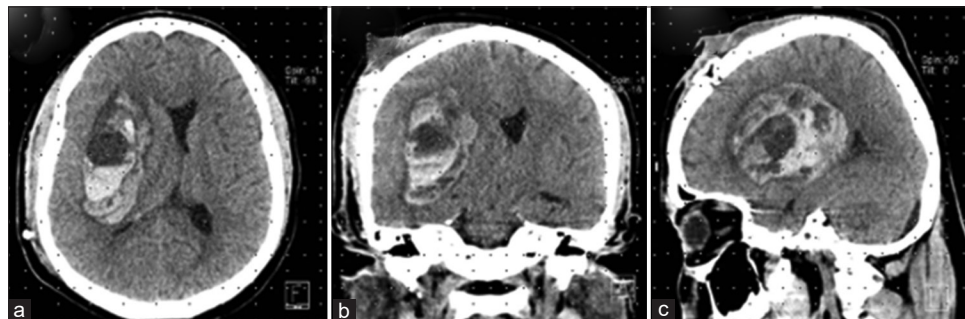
Simple computed tomography scan: (a) axial, (b) coronal, and (c) sagittal reconstructions, in which a right operculoinsular hematoma is observed. Due to the location of the hematoma, it can be suspected that the origin is from the middle cerebral artery.
